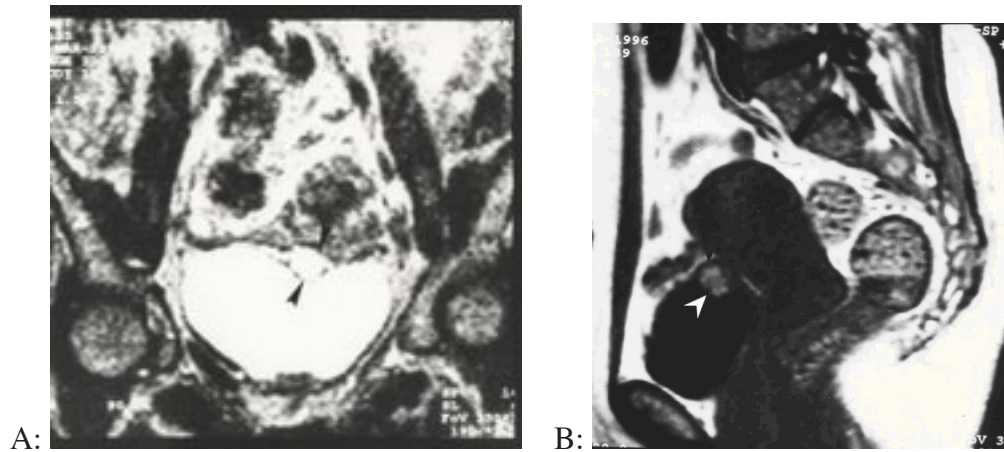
MRI: A. MRI T1. Well-circumscribed isointense mass at the bladder dome B. MRI T2. Enhancement of the mass.
